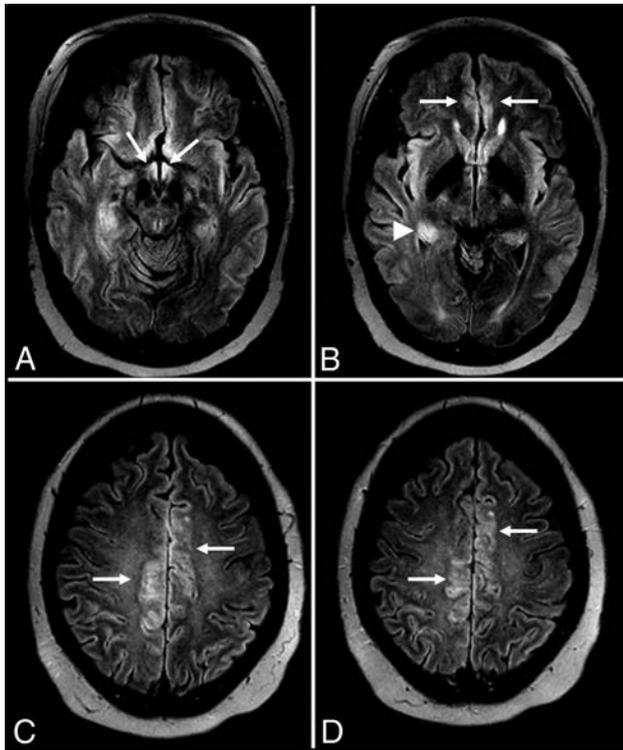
Anti-glutamic acid decarboxylase encephalitis. A 61-year-old woman presented with headaches, mild confusion, and nystagmus without development of psychosis, severe encephalopathy, or seizures. MR imaging of the brain demonstrates T2-FLAIR hyperintensity in the right > left hippocampus (A and B), right > left insular cortex (B), and bilateral cingulate gyrus (C and D) without restricted diffusion (not shown), hemorrhage (not shown), or postcontrast enhancement (not shown).
